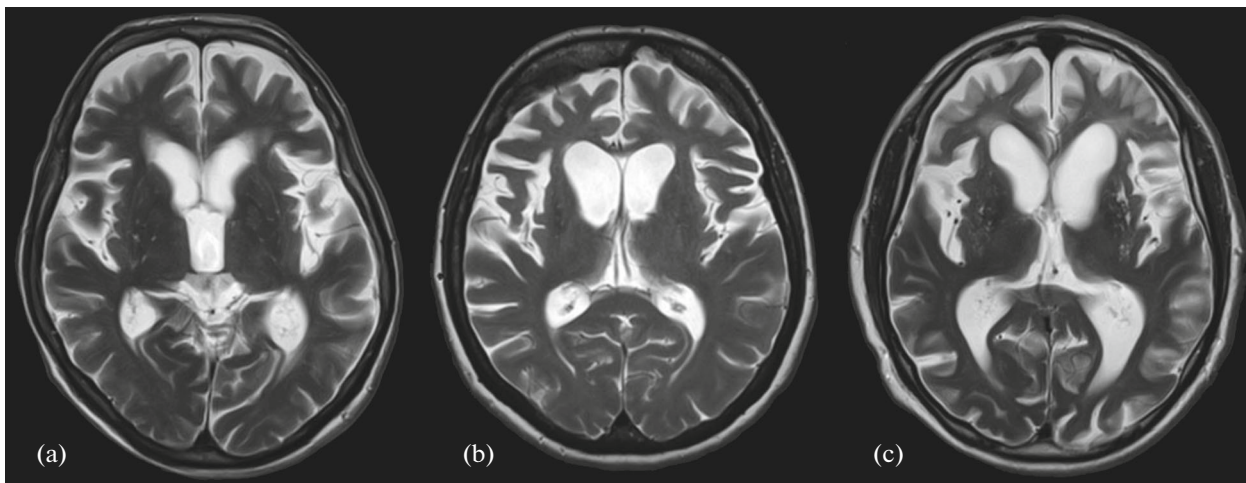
MRI of the brain in bvFTD (T2-weighted images). (a) bvFTD without pathogenic mutations in *C9orf72*, *MAPT*, *GRN* genes. (b) bvFTD associated with a mutation in *GRN* gene. (c) bvFTD associated with a mutation in *C9orf72* gene.
